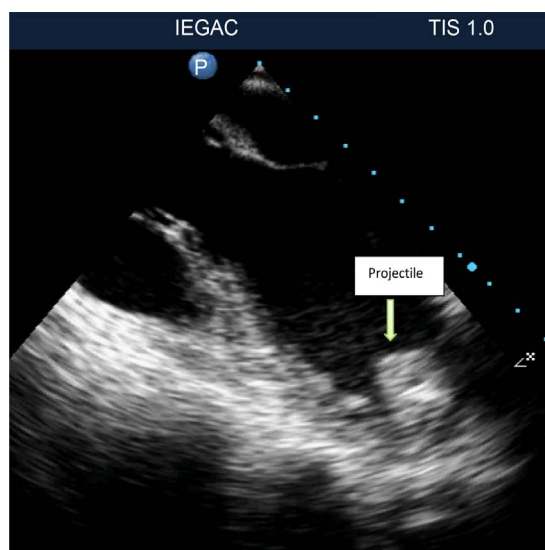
Echocardiographic image suggested a projectile in apical region.
